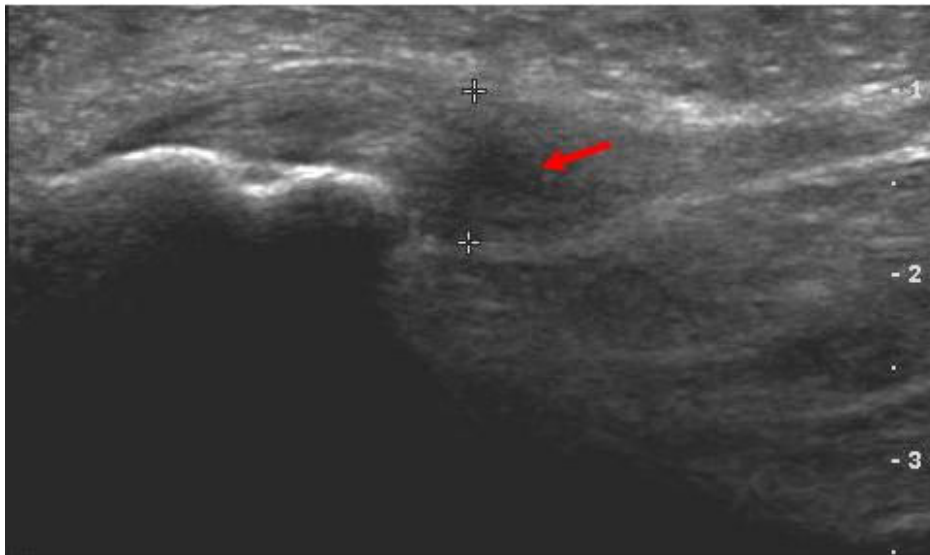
Ultrasound image of calcaneal insertion of plantar fascia with cursor markers indicating exaggerated tendon thickness and hypoechoic region.
